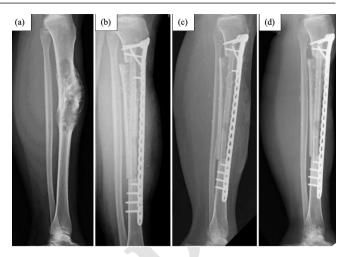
Serial X-rays of left leg: (a) The tumour was occupying the proximal and middle third of the tibia; (b) Immediate post-resection of the tumour and tibia reconstruction with the modified Capanna's technique; (c) Post-reconstruction 3 months, there was promising bone union without signs of implant failure or osteomyelitis despite on-going SSI; (d) Post-reconstruction 5 months, bone unions were noted at both ends of the allograft with thinning of the overlying skin paddle.
